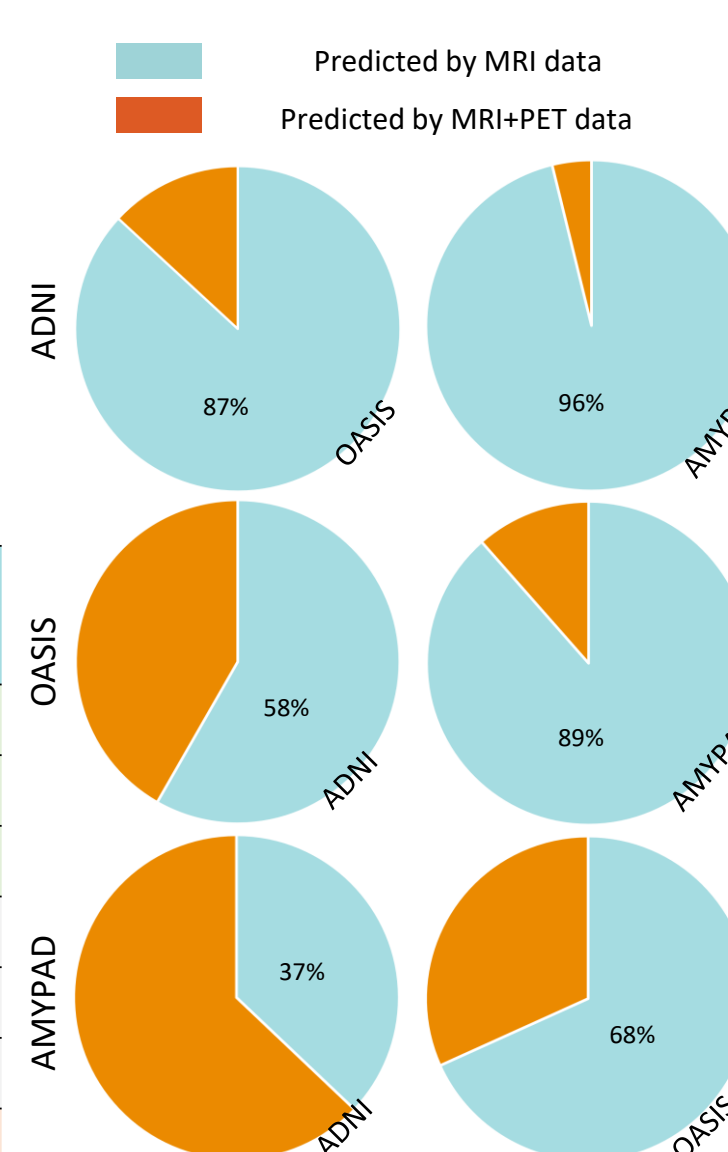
Percentage of model decisions by MRI data and subsequent confirmation by adding PET imaging. Results shown for independent validation.
